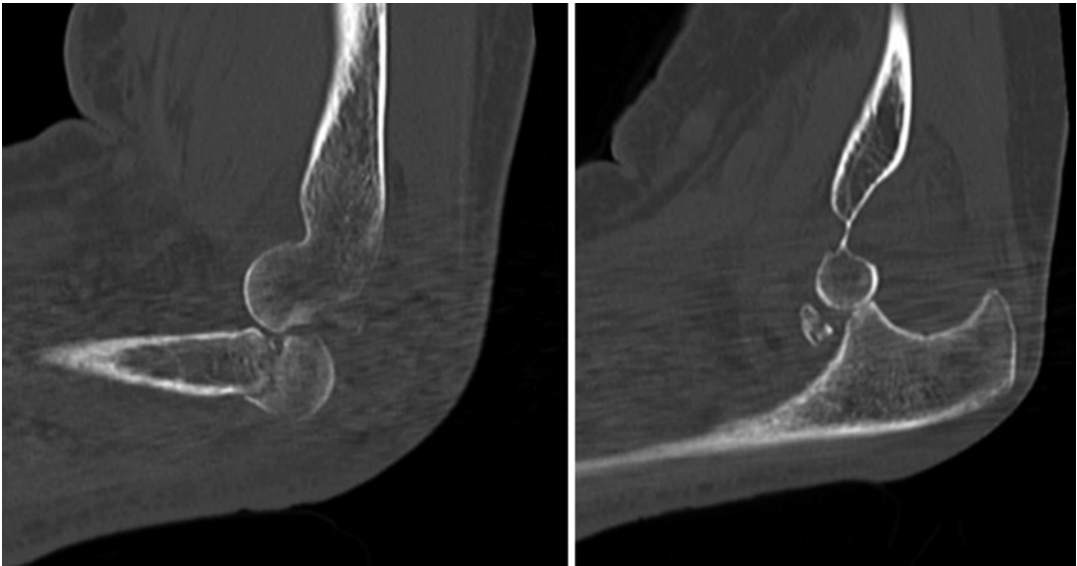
CT scan showing a typical terrible triad pattern of fracture, characterized by a fracture of the coronoid, a fracture of the radial head, and a posterior dislocation of the elbow
